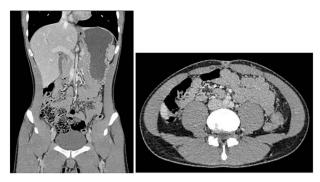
CT abdomen pelvis showing gas and fluid-filled structure in pelvis.
